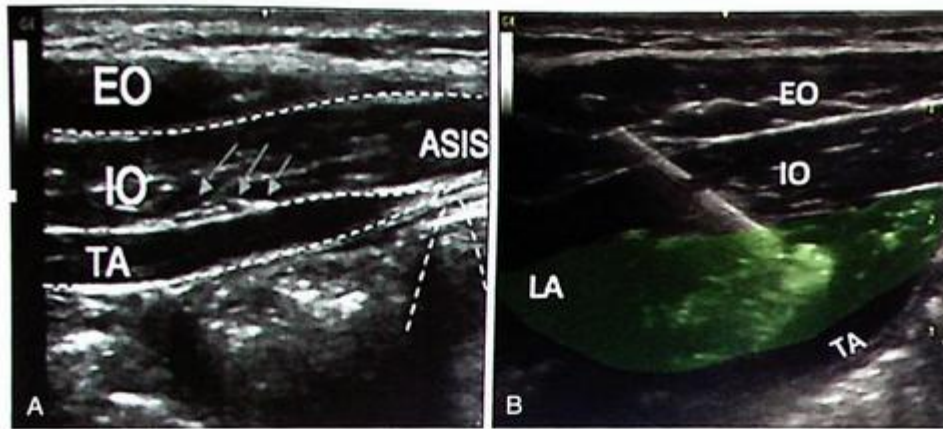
(A) The three muscles under ultrasound, visualizing the ilioinguinal and iliohypogastric nerves (arrows). (B) Local anesthetic (LA) spread between the internal oblique (IO) and transverse abdominus (TA) muscles, as shown in the image. ASIS, Anterosuperior iliac spine; EO, external oblique.
